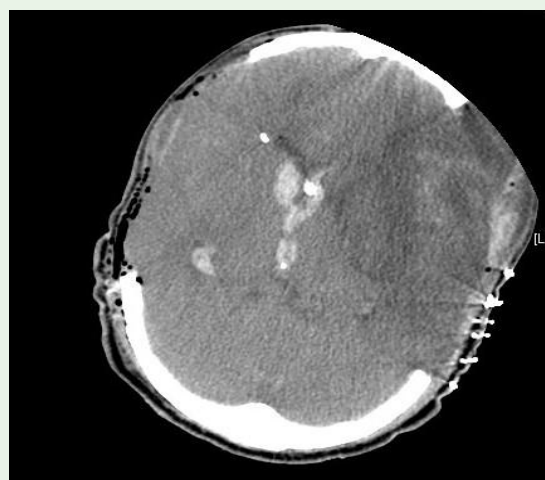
Axial non contrast CT image (5 mm) showing an extensive hypodense area with hemorrhagic elements in the left and right frontal hemisphere as well as intraventricular hemorrhage.
